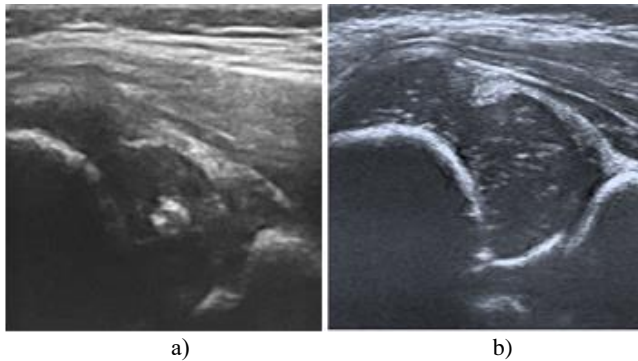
Image of the hip joint: a) the image of the hip joint in the case of the inclined position of the ultrasonic sensor head to the rear (incorrect position of the ultrasonic head sensor); b) the image of the hip joint at the correct position of the sensor of the ultrasonic head
